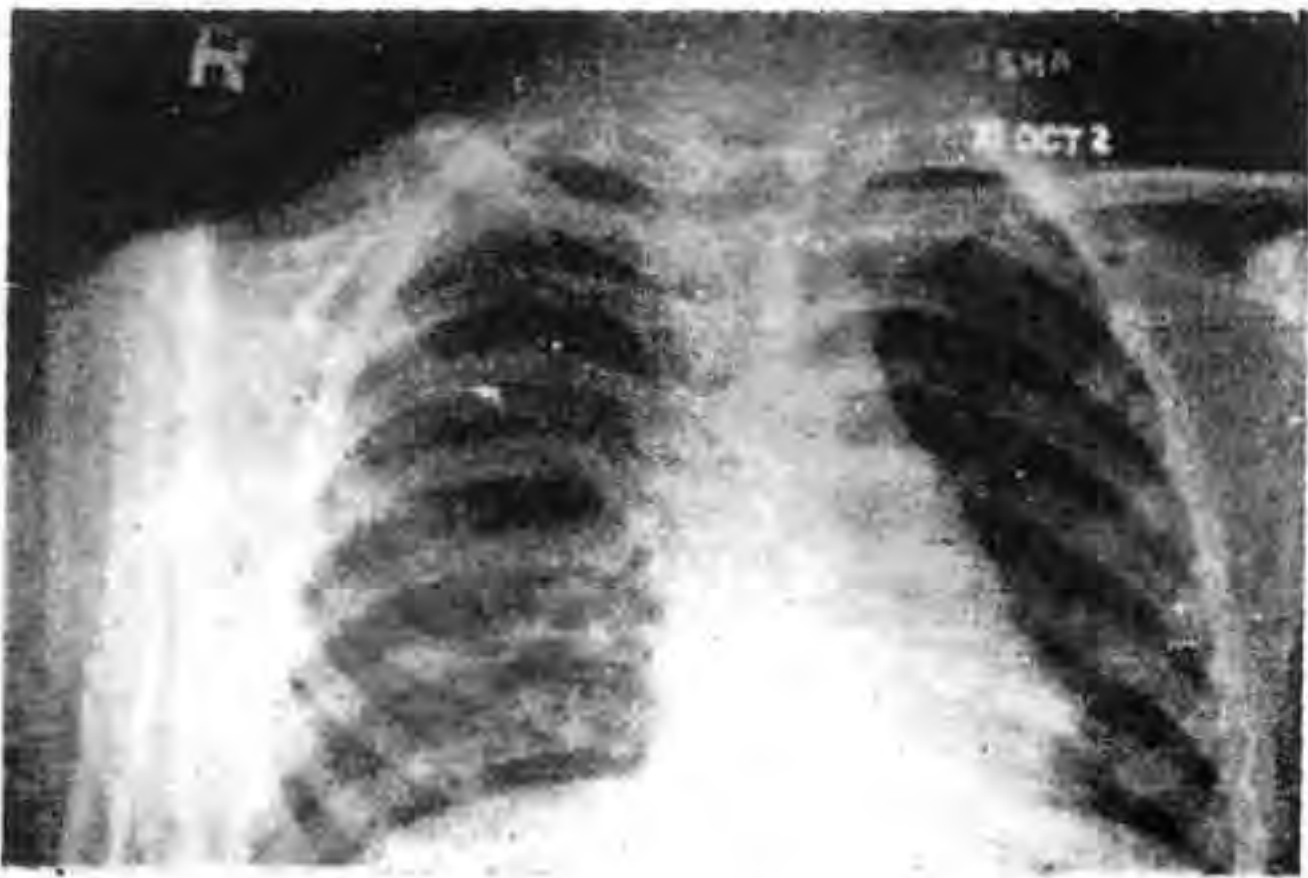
Radiograph showing pseudarthrosis of the right clavicle.
